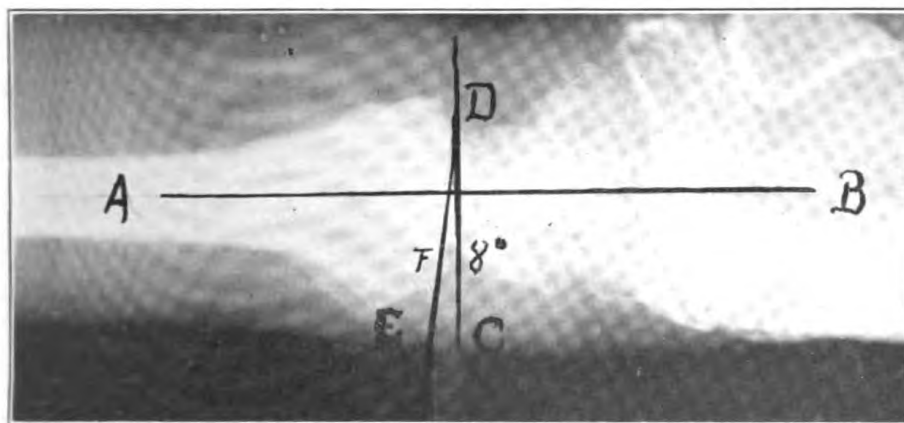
Reduction of the dislocated fragment 8° of reversal. Notice that point F is still a long distance away from the line AB. The X-ray men call such a reduction good because they rarely see any other. With such a reduction (only partial) by motion from the second day we can have a perfectly mobile wrist by the twelfth day with greater ease than with an acute-angled splint, but cosmetically there is apt to be a slight change and there will be a slight restriction in flexion. Immobilize this reduction even for two or three weeks and there will always be restriction.
